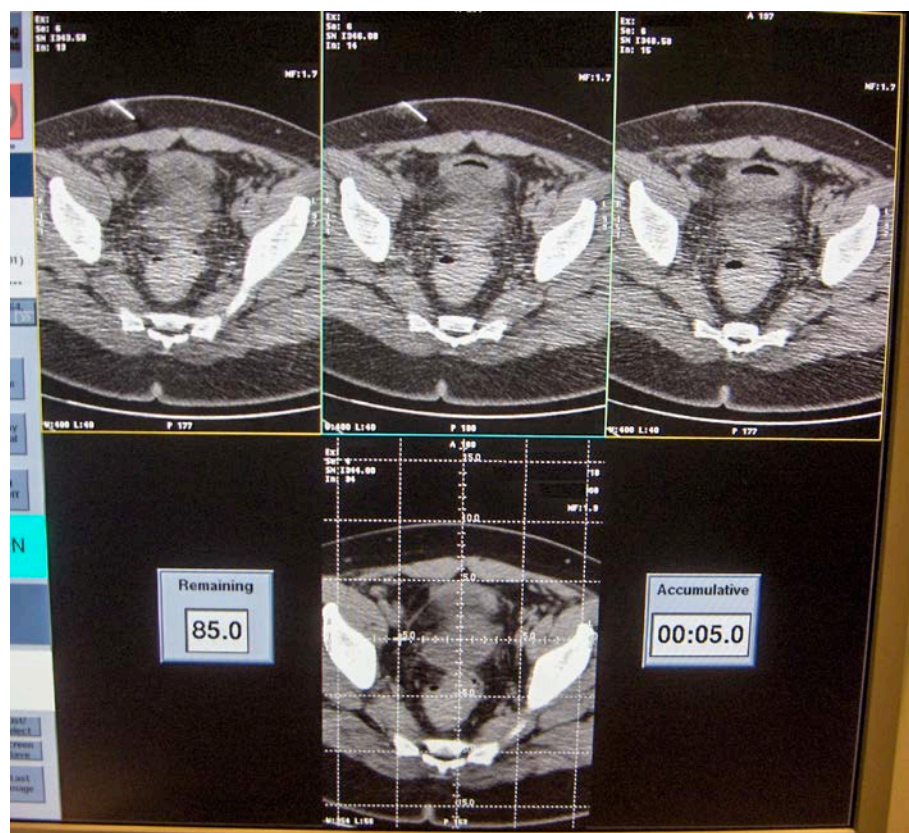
Sample images using real-time CT imaging.
